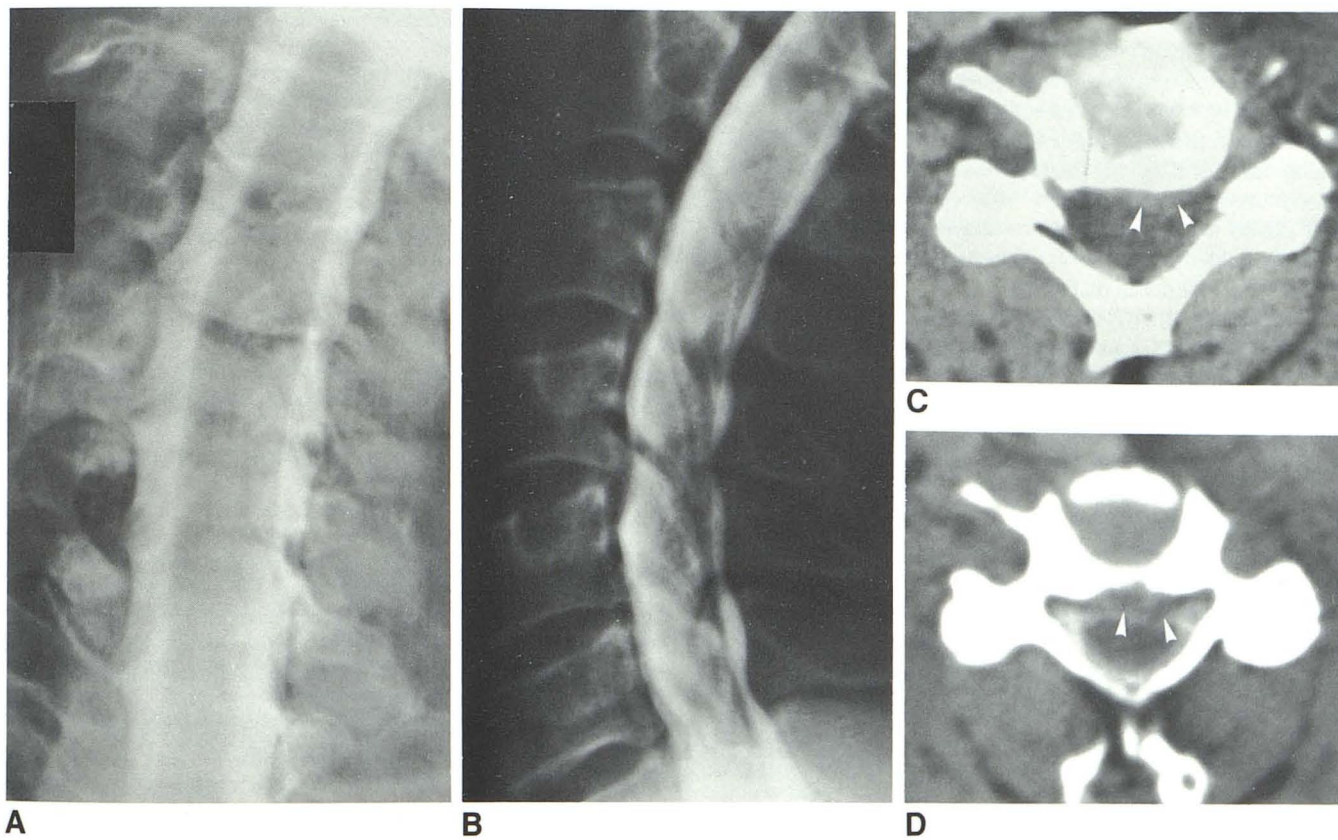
Case 3. Frontal (A) and lateral (B) cervical myelograms reveal minimal bulge at C3-C4 and C4-C5 thought secondary to osteophytes. AP film was interpreted as normal. C, Noncontrast CT scan through C4-C5 disk shows soft-tissue density posterior to vertebral body and eccentric to left.
